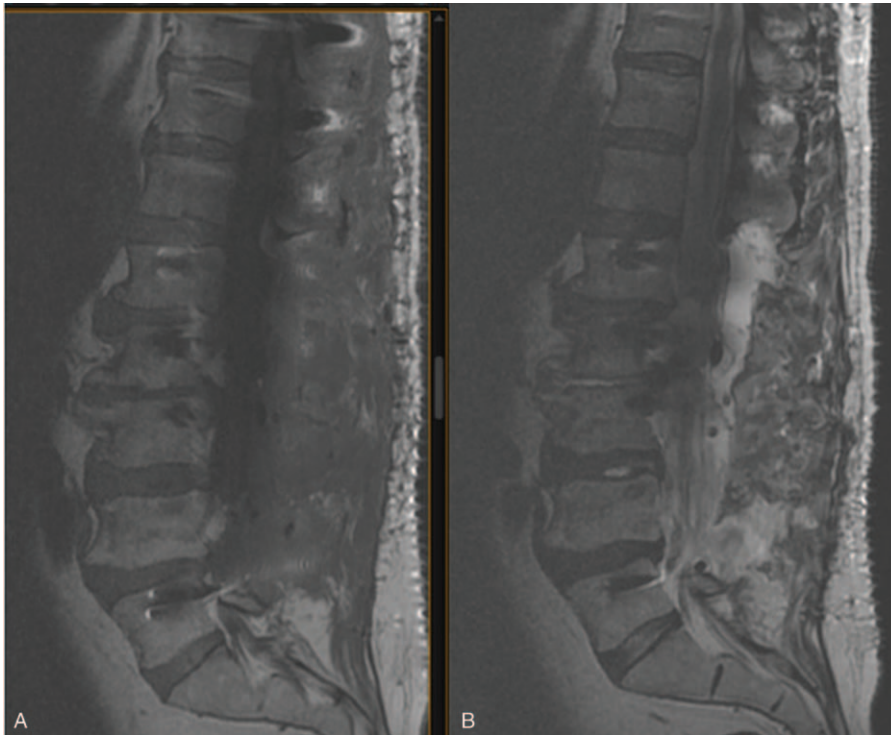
Magnetic resonance imaging T1 (A) and T2 (B) sagittal images performed immediately postoperatively demonstrated no compressive hematoma or cord signal change in the conus.
